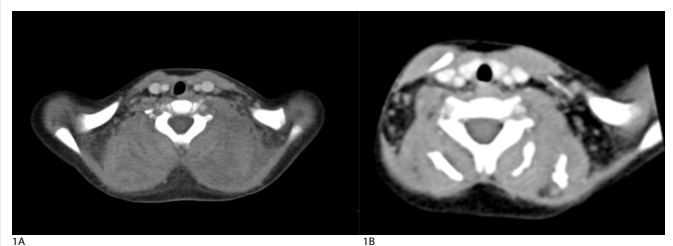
CT scan showing bilateral symmetrical enlargement of the paravertebral muscles. 1b: Follow up CT scan examination after 3 months showing development of bilateral intramuscular calcifications:
